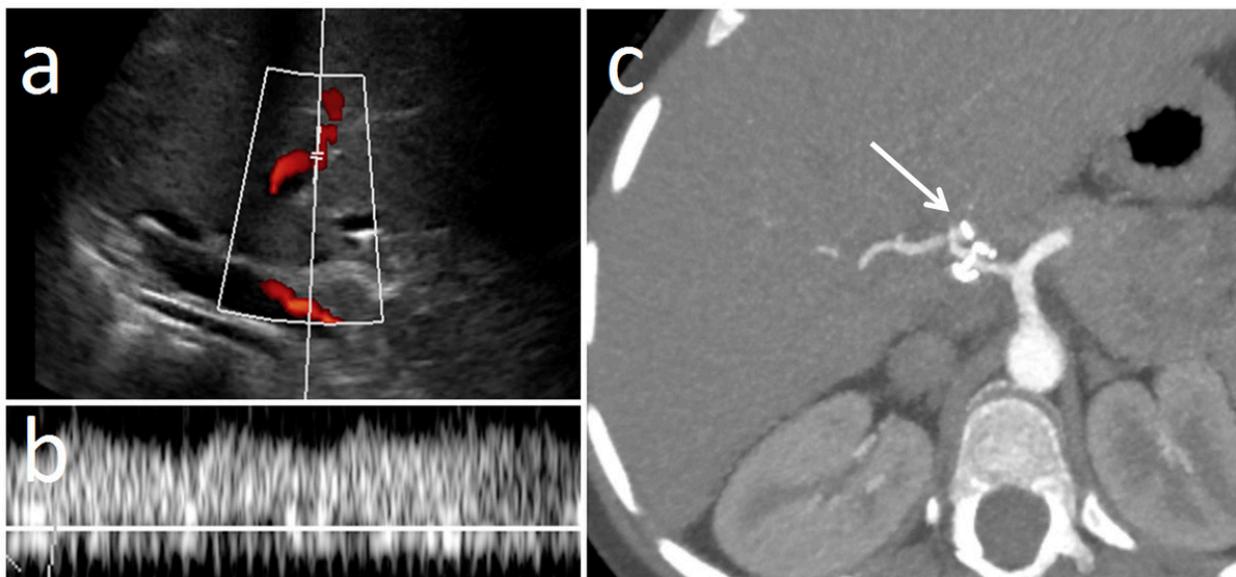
Arterial complications: Stenosis. a) Colour Doppler sonography showing the portal inflow and the Spectral Doppler box on the Hepatic Artery; b) Spectral Doppler of the arterial wave with a parvus tardus waveform; c) Axial CT with Maximum Intensity Projection showing celiac trunk and main hepatic artery, the arrow points the stenosis of the left hepatic artery.
